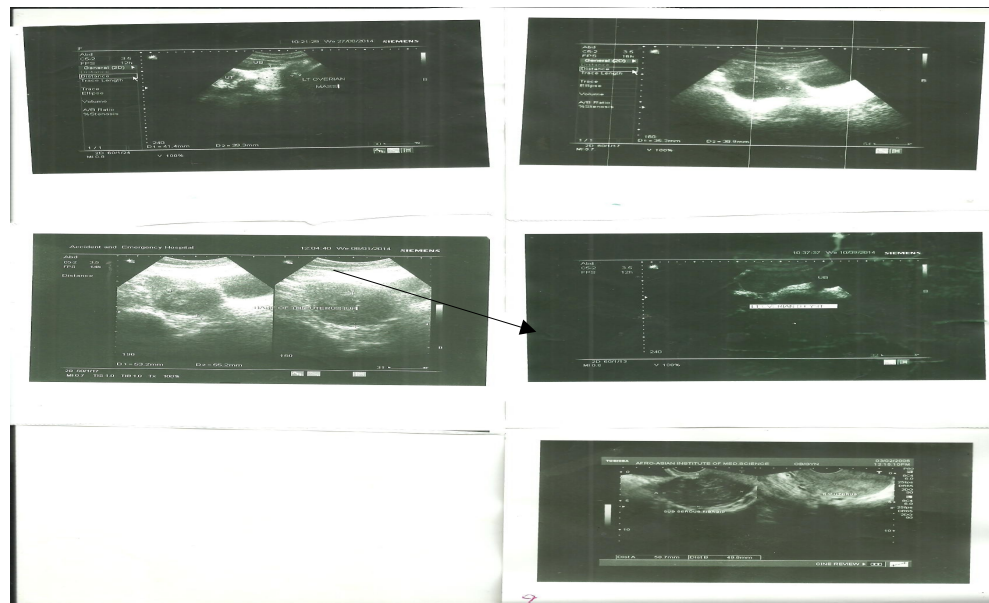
Figure eight: 35 old Ultrasound show ovarien mass
